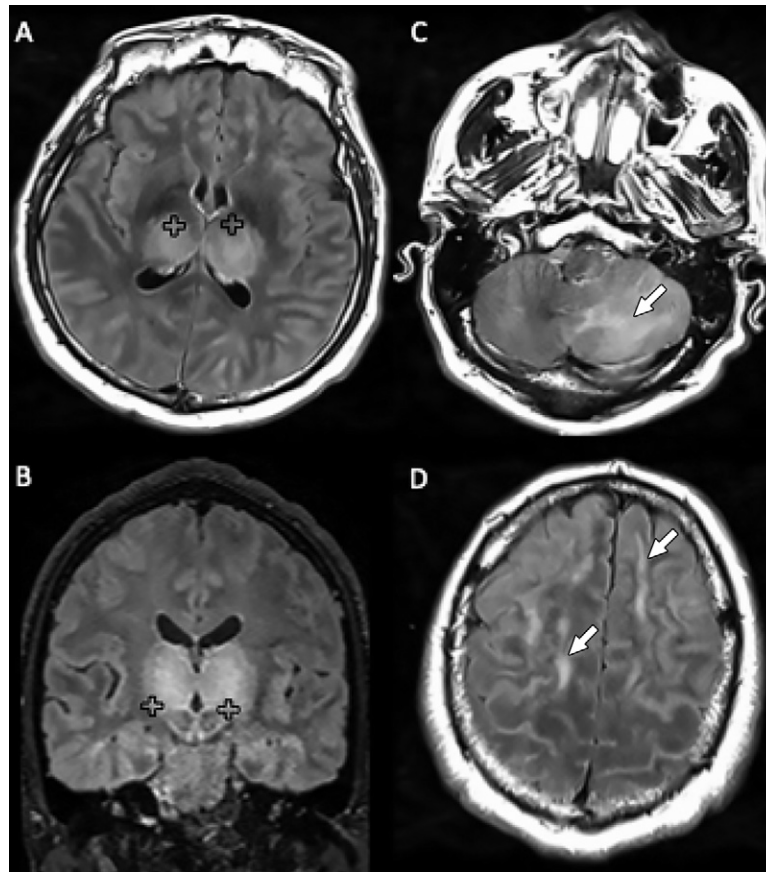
Images in a 51-year-old man with impaired consciousness and acute necrotizing encephalopathy. A, C, D, Axial fluid-attenuated inversion recovery (FLAIR), and B, coronal FLAIR images show bilateral FLAIR hyperintensity (+) in A, B, both thalami associated with involvement of the C, cerebellar, and D, cerebral white matter (arrows).
